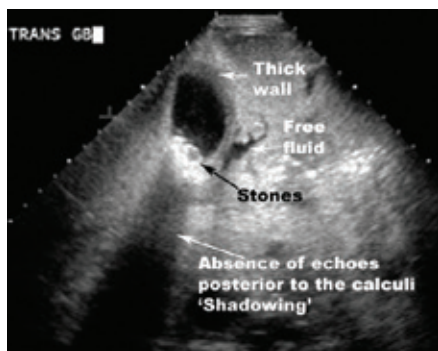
Ultrasound image showing acute cholecystitis (inflammation of the gall bladder) with gallstones in the gallbladder lumen.
